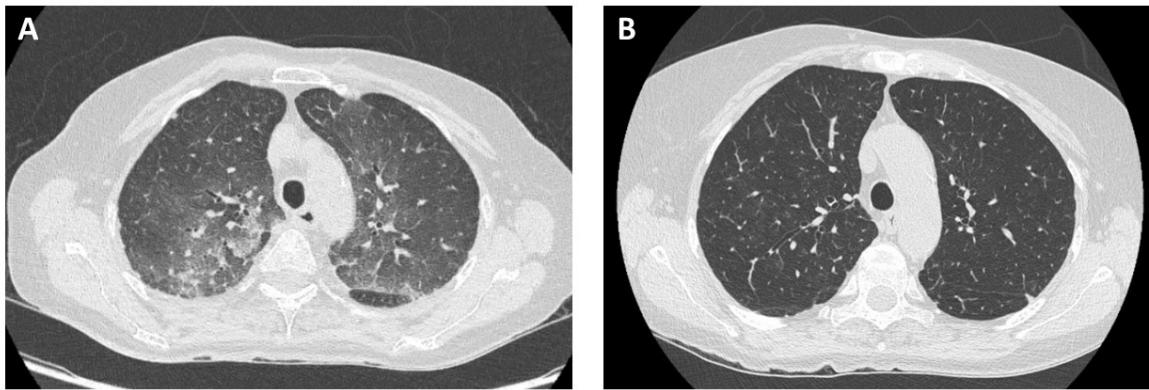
A. Chest CT showing diffuse patchy ground glass opacities. B. Chest CT showing complete resolution of interstitial infiltrates at three months follow up.
